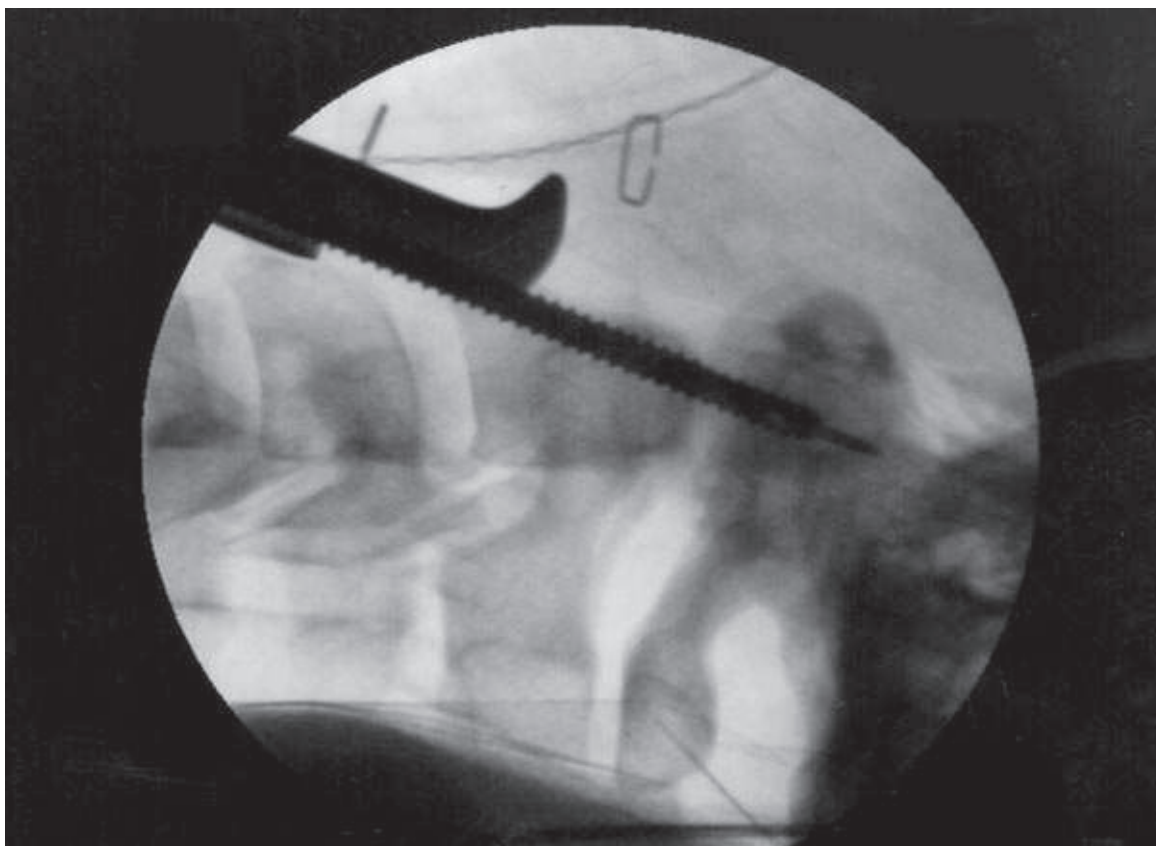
Lateral radiograph showing the guide wire in place, spanning the fracture line in the odontoid process with a cannulated tap being advanced along the wire.
